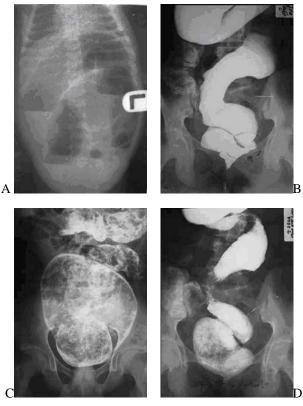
HD A: a plain x-ray abdomen showing marked gaseous distension. B, C & D: Barium enema showing the site of transition zone.
